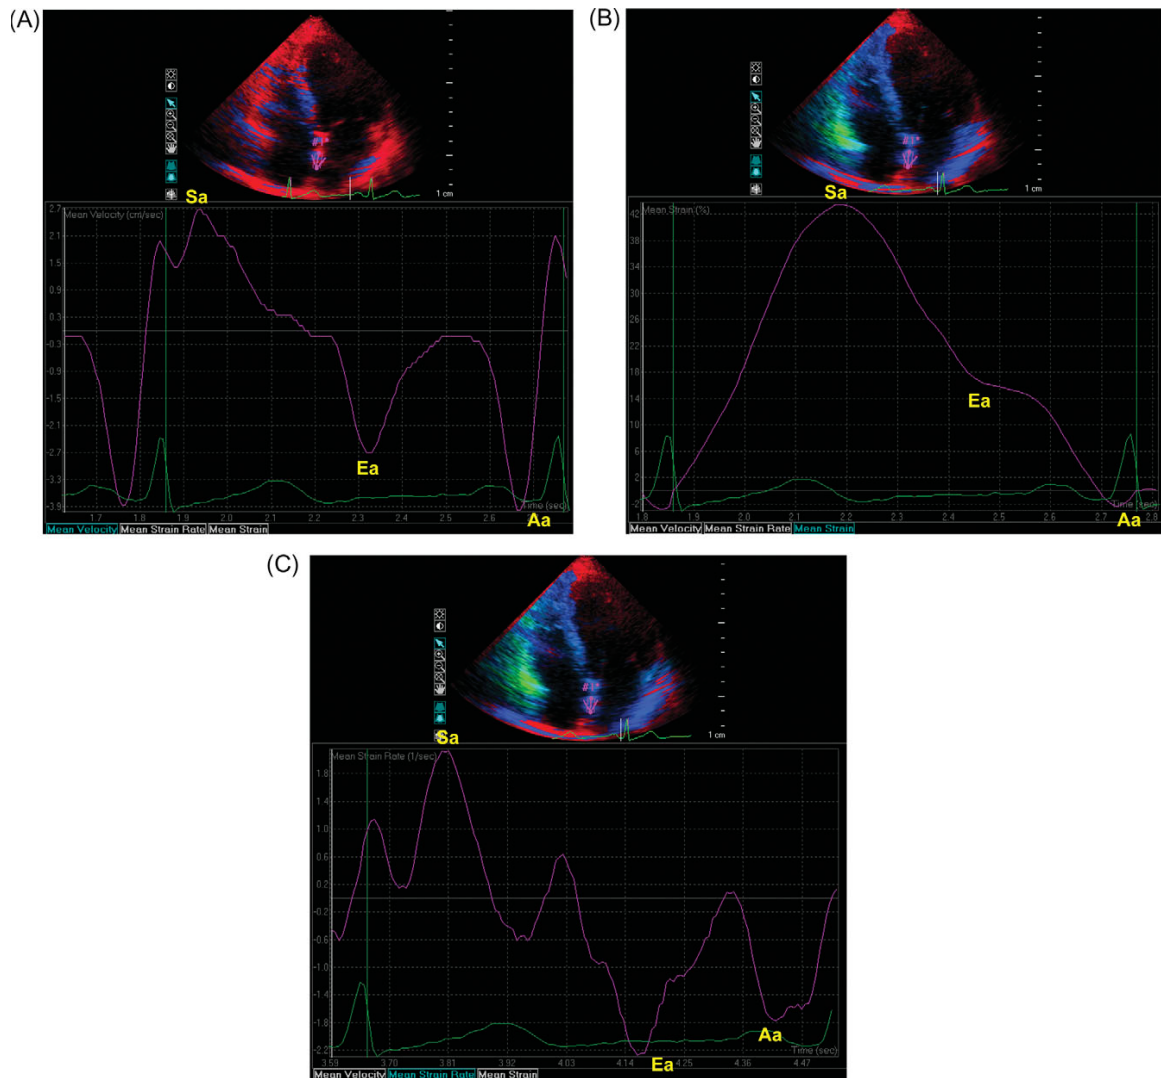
Assessment of regional atrial myocardial function by tissue Doppler imaging. The sample volume was placed at the mid-level of inter-atrial septum on colour tissue Doppler imaging image to reconstitute the myocardial velocity (A), strain (B), and strain rate (C) curves. They consist of ventricular systolic (Sa-wave), ventricular early diastolic (Ea-wave), and late diastolic (atrial contraction, Aa-wave) components
